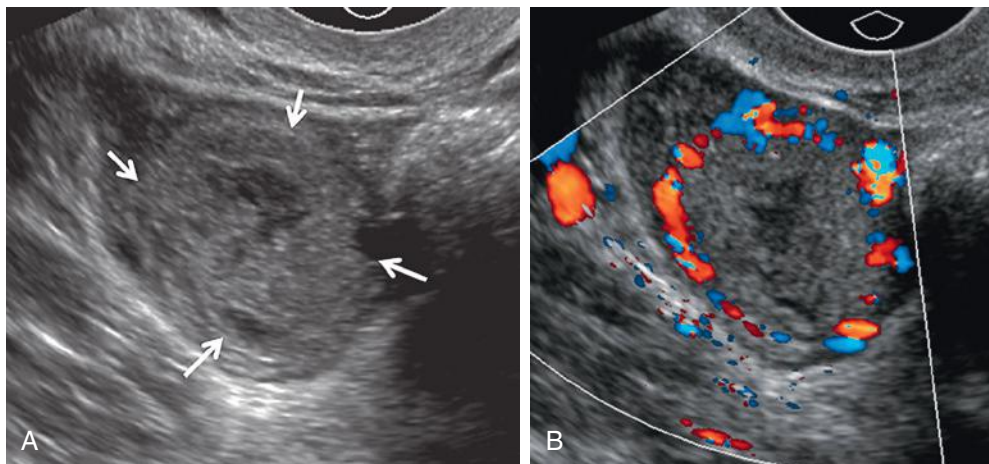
Corpus luteum. A, Transvaginal sonogram demonstrating a slightly echogenic lesion within the right ovary (*arrows*), with a complex cystic central component and thick homogeneous wall. B, Color Doppler imaging shows markedly increased blood flow in a peripheral ring-like pattern, sometimes described as a "ring of fire," a characteristic appearance of the corpus luteum.
